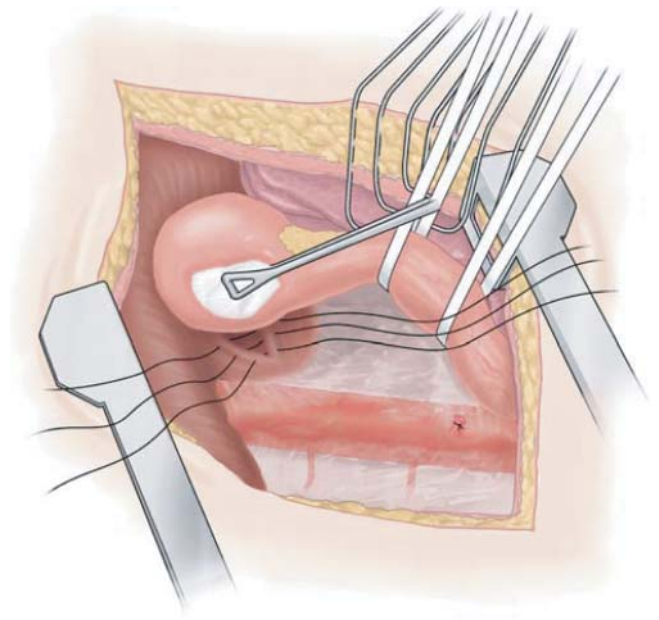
Transthoracic hiatal hernia repair. The esophagogastric junction is mobilized by dividing the phrenoesophageal ligament and some short gastric vessels. No. 1 silk sutures are passed through the exterior aspect of the right crus (with care taken to avoid the adjacent inferior vena cava) and through the left crus.
